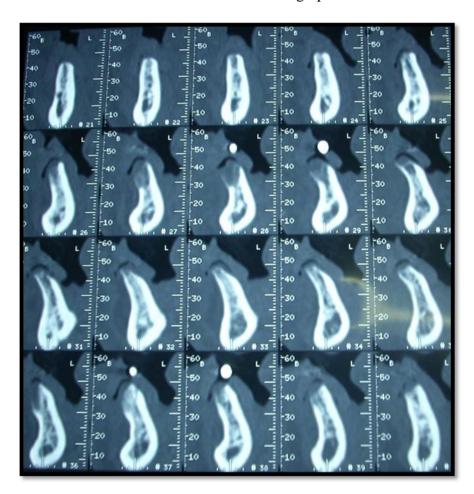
CT scan with radiographic stent in place
